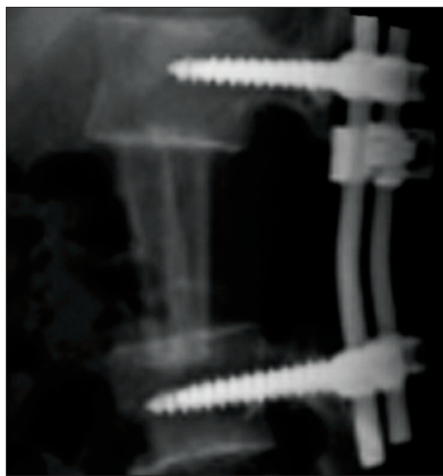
Postoperative lumbar lateral X-rays shows the costal bone grafts replacing the L2 vertebral body and the posterior L1-L3 transpedicular screws fixation
